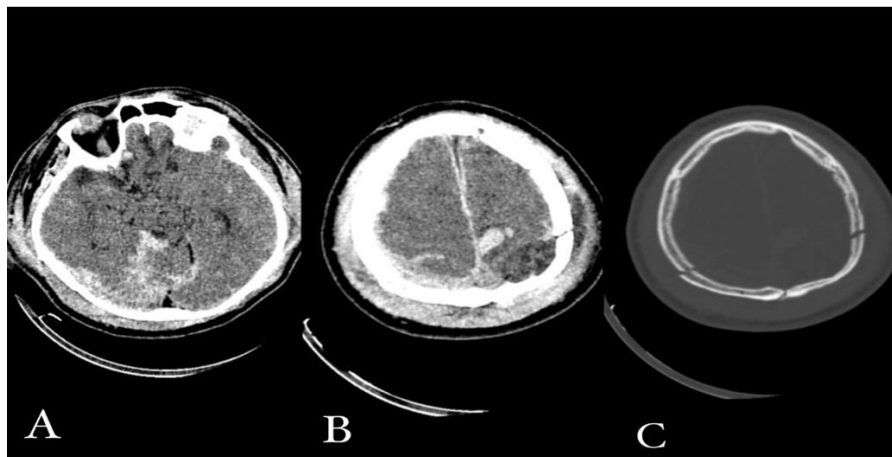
CT scan performed with polytrauma protocol, non-contrast scans. Patient injured in car accident. CT scans show two systems affected, brain and skeletal trauma. Subarachnoid hemorrhage supratentorially and temporally was seen (A) with intracerebral hemorrhage in the parietal left lobe (B) and hemorrhage in parafalx area. Axial plane at bone window shows parietal bone fracture (C).
